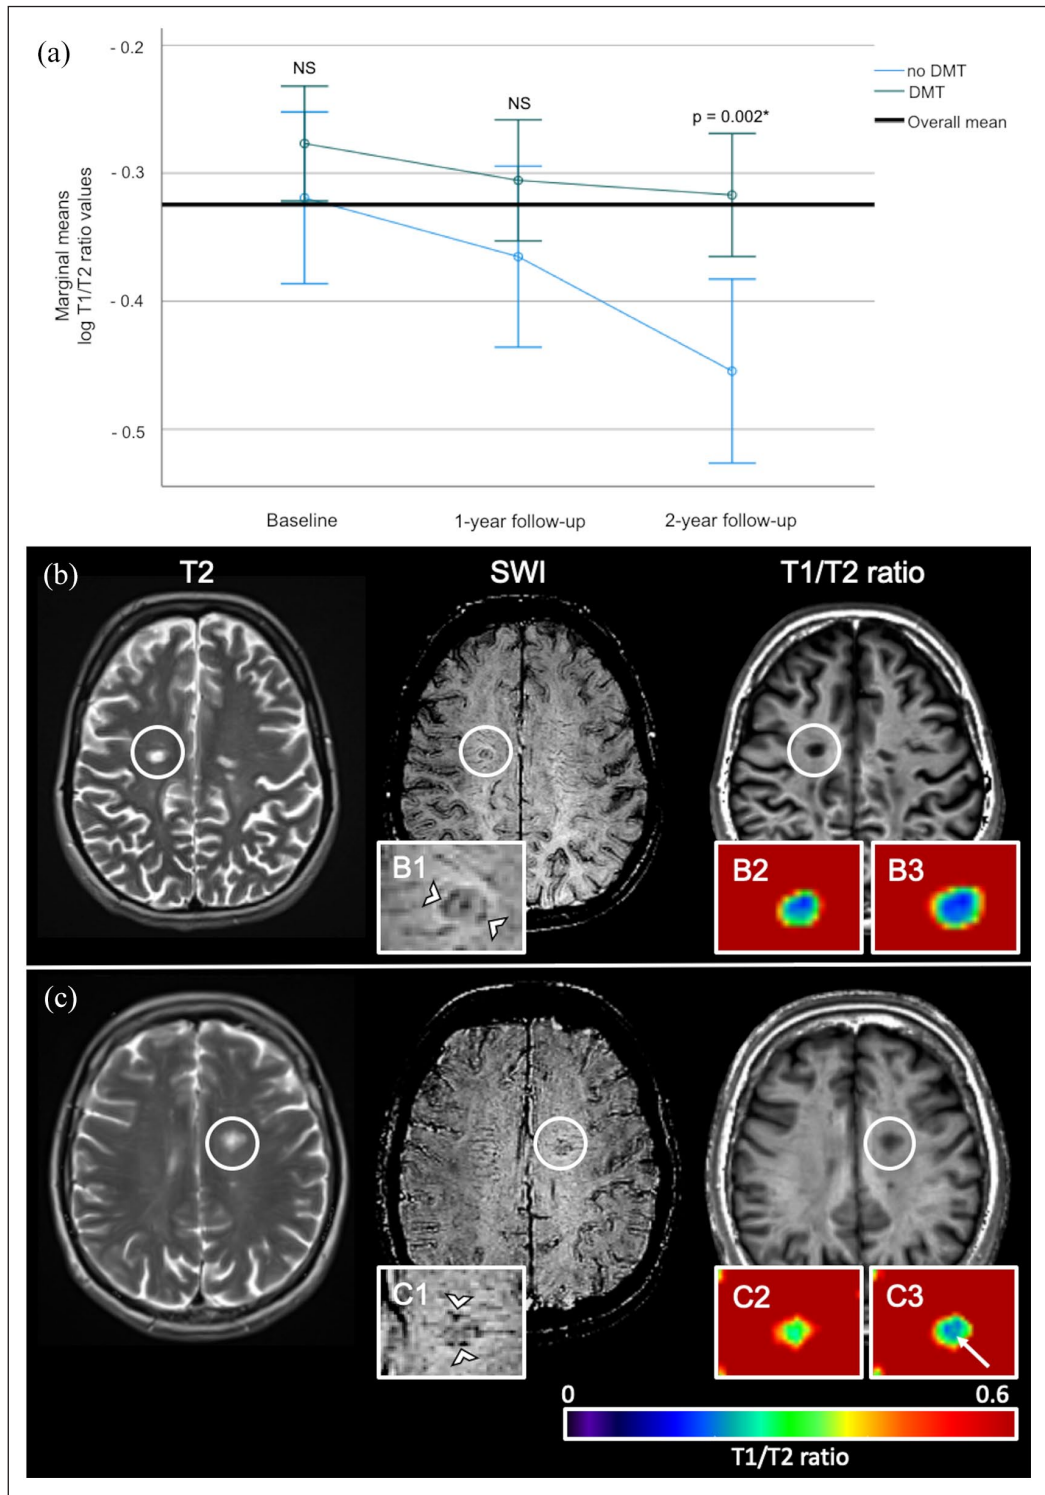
(a) Plot of log-transformed T1/T2 ratio values in iron rim lesions at baseline and follow-up. (b) and (c) From left to right: T2-weighted, susceptibility-weighted images (SWI) and magnification, and T1/T2 ratio maps in a patient starting DMT with fingolimod (b) and a patient without DMT (c). SWI and magnification (B1 and C1) demonstrate the representative examples of iron rim lesions (arrowheads). Color-coded T1/T2 ratio maps at baseline (B2 and C2) and at the 2-year follow-up (B3 and C3). Note the pronounced decrease of T1/T2 values during follow-up in the patient without DMT (arrow).
